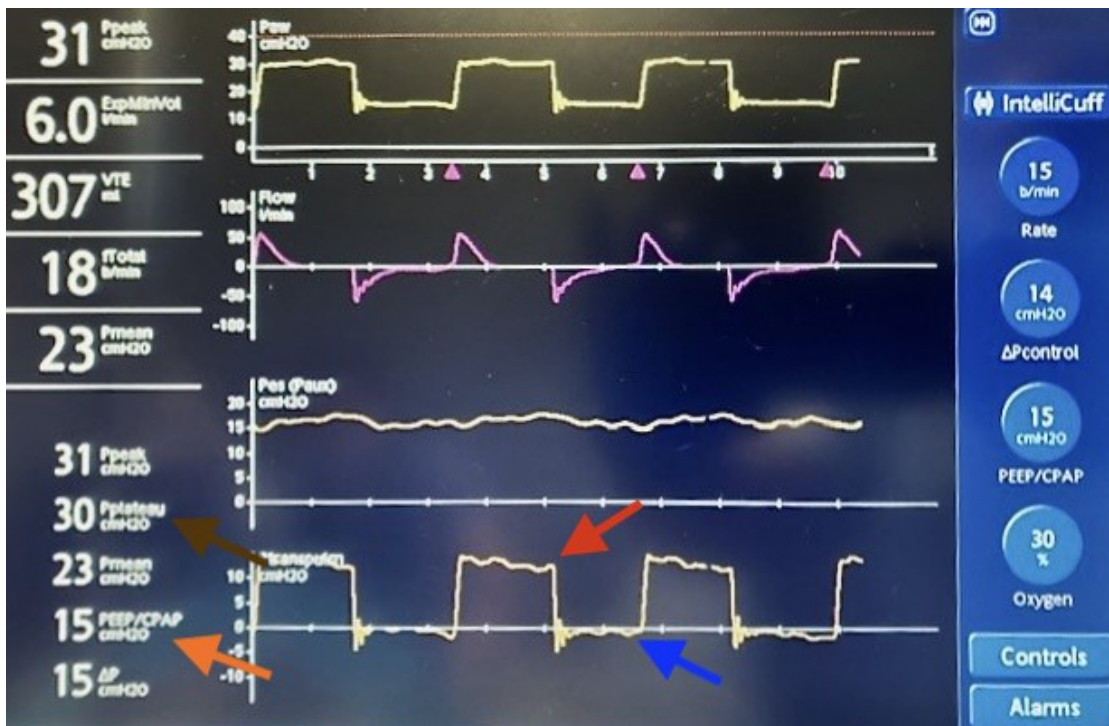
A: Ventilator settings of interest in the patient with both transesophageal balloon (third line down), calculated transpulmonary pressure (fourth line down). Note: tidal volume (VT, 307ml), respiratory rate (18), plateau pressure (brown arrow: 30cmH₂O), PEEP (orange arrow: 15cmH₂O), transpulmonary end inspiratory pressure (red arrow: 13 cmH₂O), and transpulmonary end expiratory pressure (blue arrow: - 1.4 cmH₂O).
